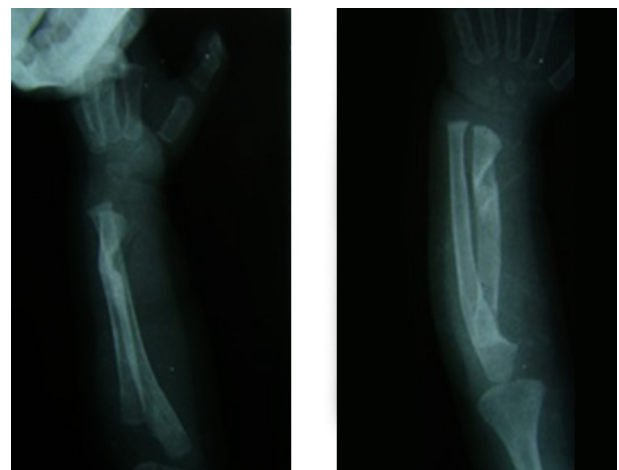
Radiographic Appearance of FFCD in Distal Radius, Case No. 1
